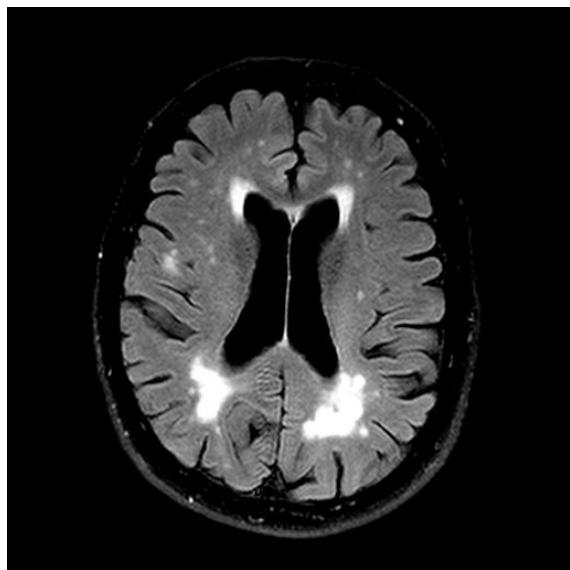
MRI scans of patients 1 (JPN) and 2 (CM) at entry (left column) and at follow-up (right column), 18 months later.
